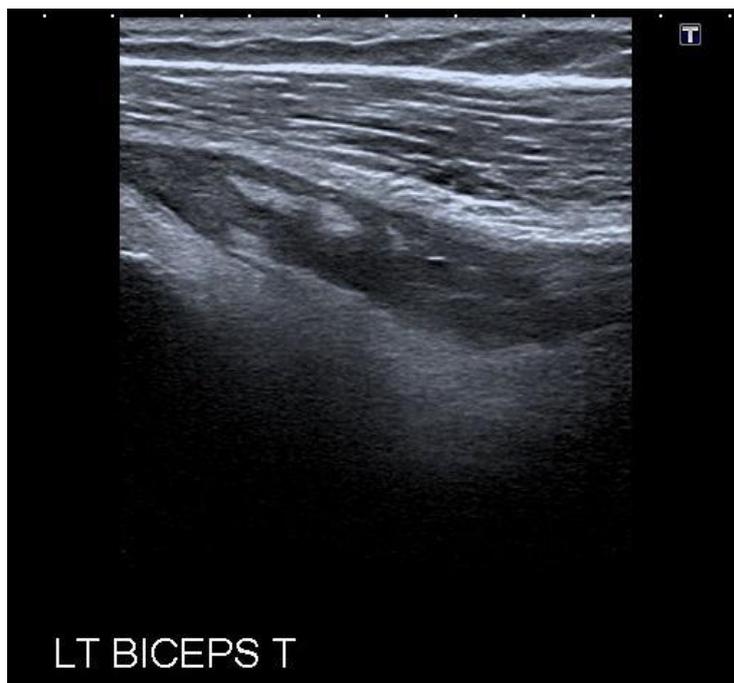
Ultrasound image of ruptured biceps tendon and haematoma.
